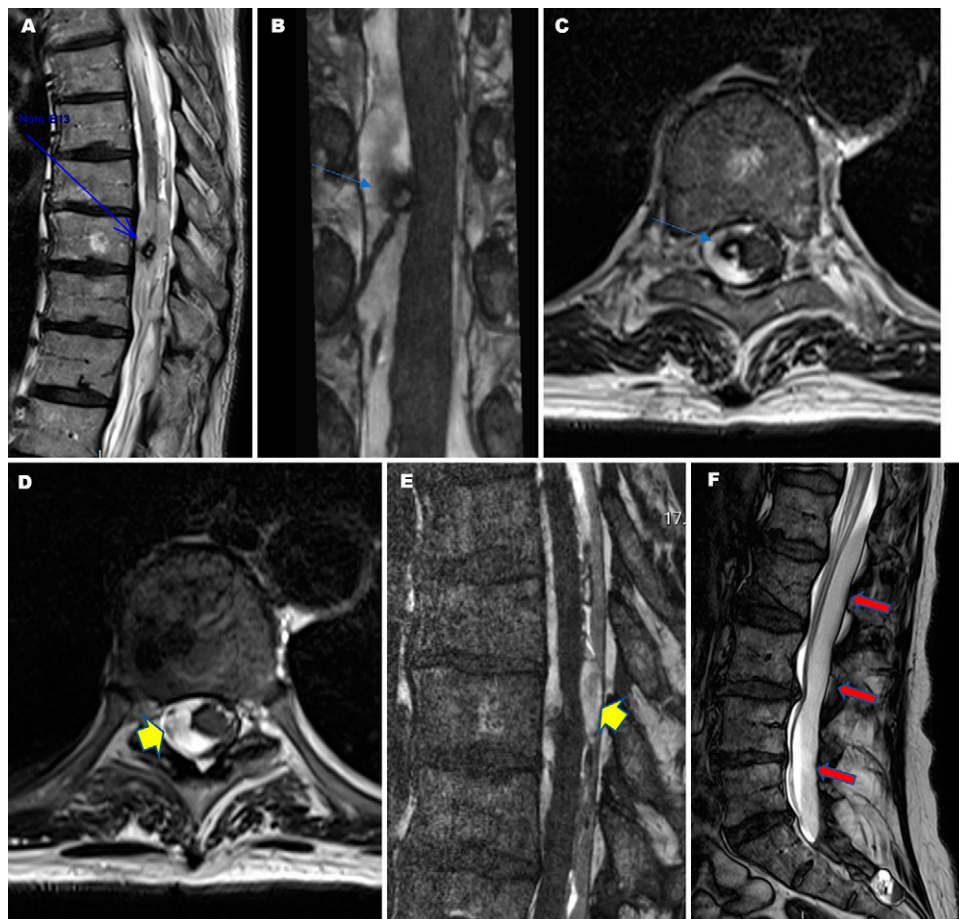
Initial spinal MRI. A: A centimetric extramedullary cavernoma (arrow) at the T9 level. B: The cavernoma in relation to the T9 root (blue arrow). C: Axial T2-weighted imaging showing slight compression of the spinal cord on the right side. D: Axial MRI at the T10 level showing a thickened arachnoid pouch (arrow). E: Multiple pouches of thickened arachnoid and extensive SAH (arrow). F: Extensive blood (arrows) at the cul de sac on lumbar sagittal MRI.
